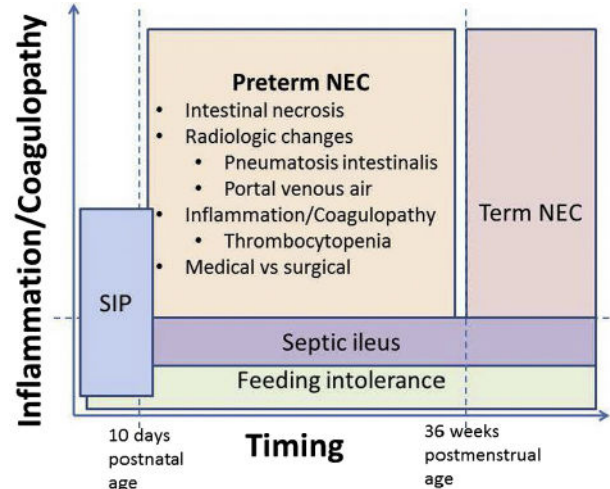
Proposed diagnosis of preterm NEC requires: (1) signs (abdominal distention and/or hematochezia); (2) timing (between postnatal day 10 and 36 weeks corrected gestational age; most common between 30–32 weeks postmenstrual age); (3) at least 1 of the following: (a) intestinal necrosis at laparotomy or autopsy; (b) either pneumatosis intestinalis or portal venous air (by radiograph or ultrasound); or (c) evidence of vasculitis, coagulopathy, or inflammation in the absence of bacterial, fungal, or viral infection.
